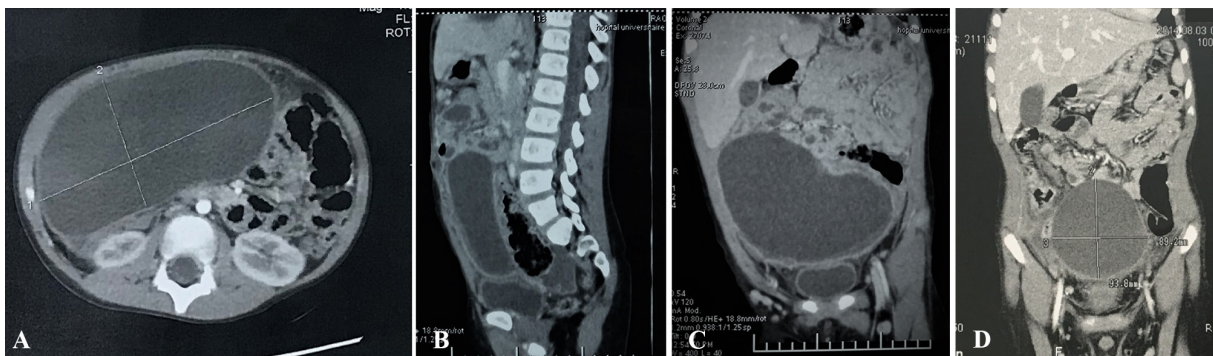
A) Computed tomography reveals a cystic mass adherent to the liver and the right ovary, B) Computed tomography reveals a cystic mass adherent to the liver and the right ovary, C) Computed tomography shows a large peritoneal cyst. D) This figure shows an image of a pelvic hydatid cyst.
